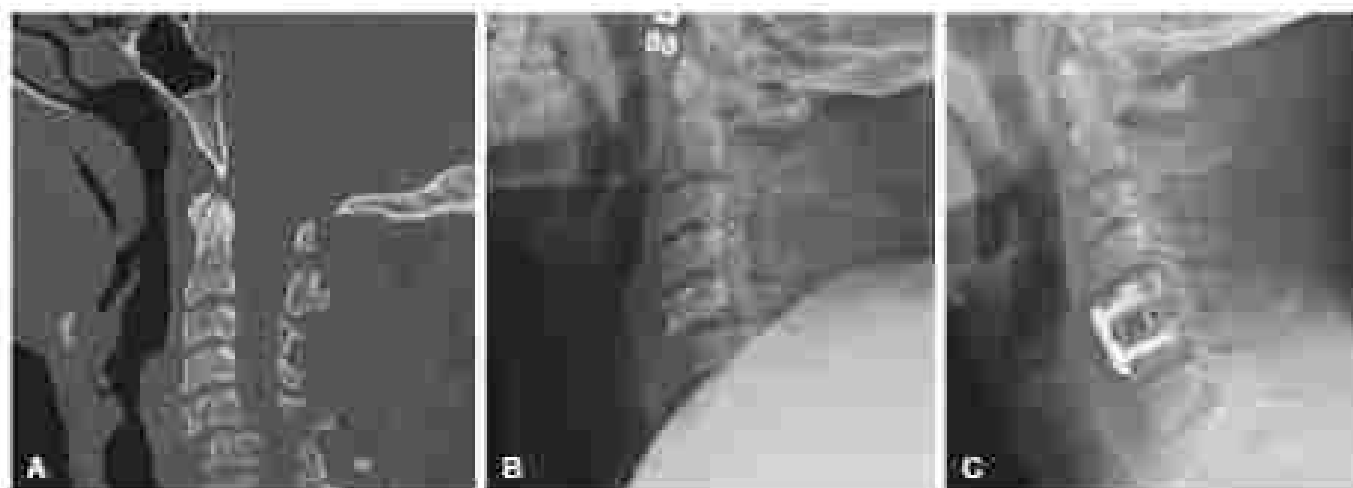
Lateral cervical spinal cord injury. This patient presented to the emergency department (ED) as a pedestrian versus motor vehicle accident. Computed tomography scan (A) and radiographs (B and C) demonstrated C5-C6 lateral flexion facets with relative interposition of C6 on C5 with complete spinal cord injury at C6 level (American Spinal Injury Association score A). The injury was reduced to the ED using serial traction. Later that day, the patient had definitive fixation with a C5-C6 anterior cervical discectomy and fusion.
